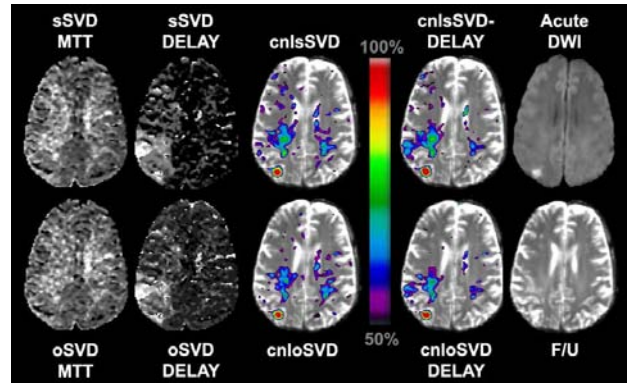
Example acute DWI and PWI maps calculated using an AIF from the contralateral hemisphere and deconvolution with sSVD and oSVD and their corresponding predicted infarction. A clear PWI/DWI mismatch is present. Note that adding DELAY as an additional covariate improves the specificity of the predictions resulting in risk maps which match better with the 5 day F/U. Relying on only DWI would have underestimated the lesion, and only on DELAY would have overestimated it.
